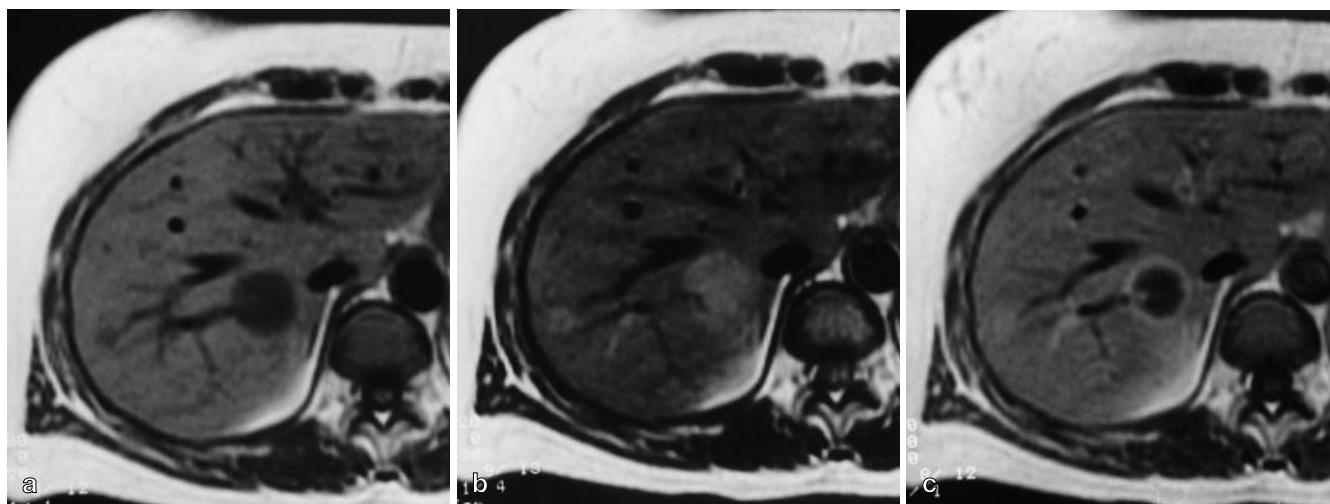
Epithelioid hemangioendothelioma. a On the T1-weighted image, two hypointense nodules are detected. b The lesions appear hyperintense on the T2-weighted image. c Delayed contrast-enhanced T1-weighted image shows peripheral, rim-like enhancement in the larger lesion, and homogeneous enhancement in the smaller lesion
